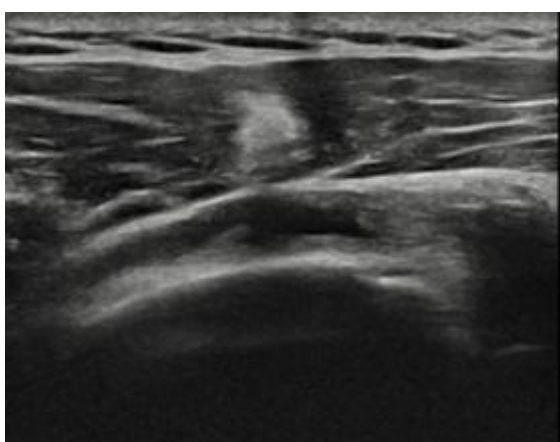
Longitudinal ultrasound of the supraspinatus tendon showing a discrete irregular hypoechoic focus, consistent with partial thickness tendon tear.
